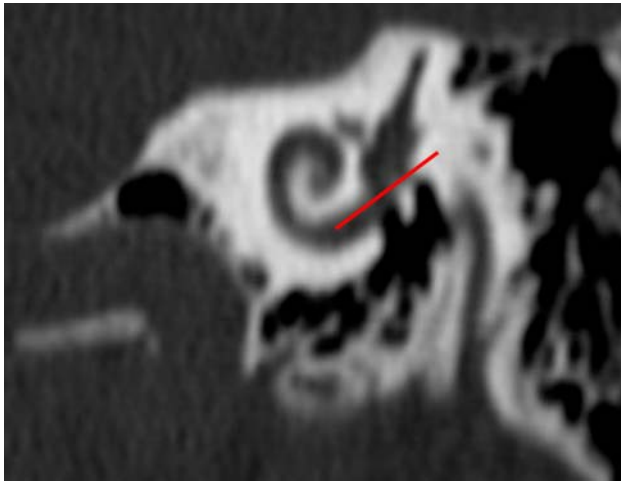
Red line EMA insertion plane. Oblique CT scan, left ear (Courtesy of Instituto Gamma, Rosario)
